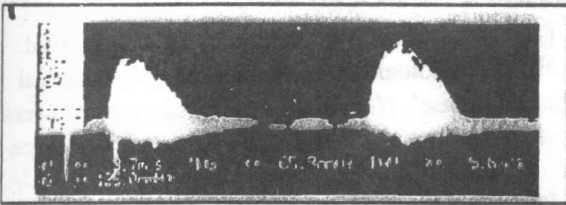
Continuous wave Doppler recording of the aortic velocity in a patient with aortic stenosis.
